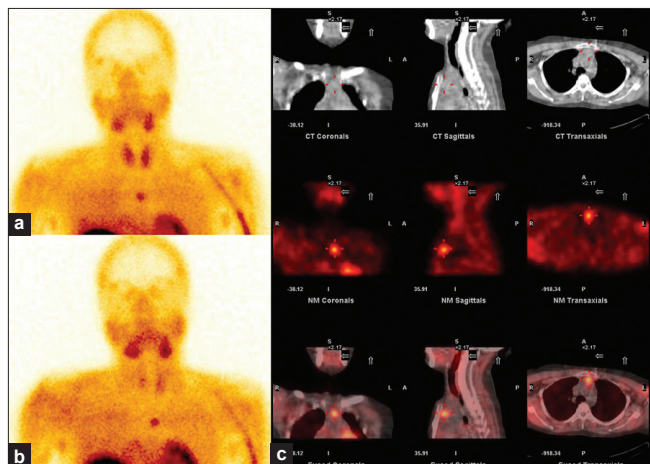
A 37-year-old female presented with hypercalcemia with raised PTH. USG of the neck was normal. (a and b) Dual-phase Tc99m sestamibi scan showed ectopic functioning parathyroid tissue in the anterior mediastinum. (c) Hybrid SPECT/CT localizes the area of hypermetabolic focus in the anterior mediastinum
